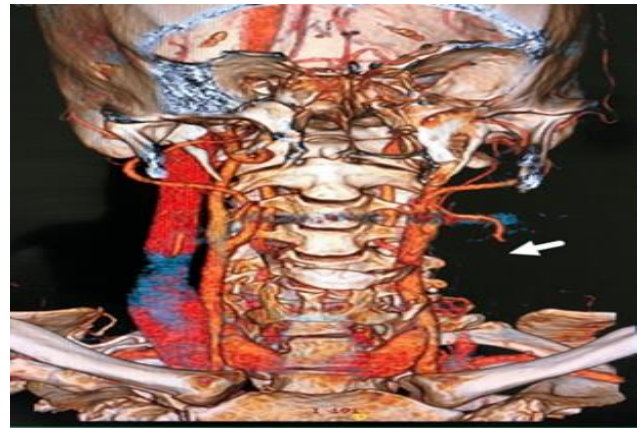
CT neck angiography with 3D reconstructed coronal image; arrow demonstrating extensive thrombosis of IJV, jugular bulb and sigmoid sinus on left side.
